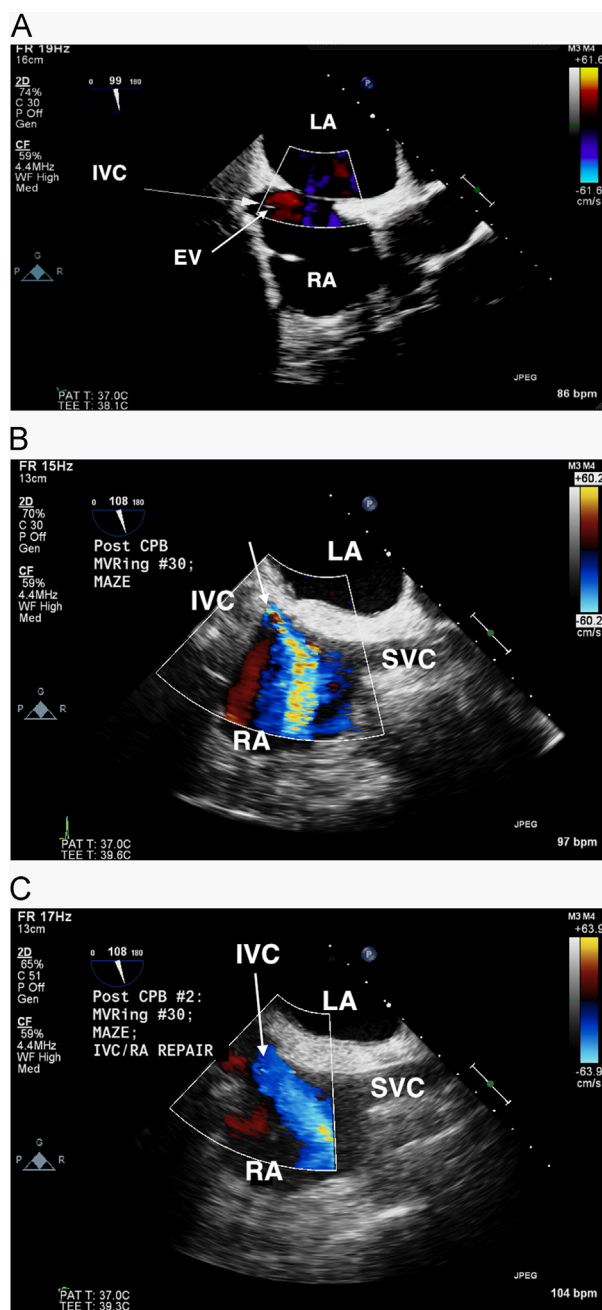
TEE in the midesophageal bicaval view of the IVC-RA junction. (A) The IVC-RA junction before bypass measured 15 mm and demonstrated laminar flow. The eustachian valve (EV) is also seen. LA, left atrium. (B) Color-flow Doppler imaging after the first bypass demonstrates aliasing and turbulence of the venous return (arrow) from the IVC into the RA that is suggestive of restriction. Measurement of the IVC-RA junction confirmed narrowing at 7.1 mm (not shown). (C) Color-flow Doppler imaging after release of the entrapped eustachian valve shows disappearance of the high-velocity inflow jet from the IVC. Measurement confirmed an increased diameter at the IVC-RA junction of 14.7 mm (not shown).
